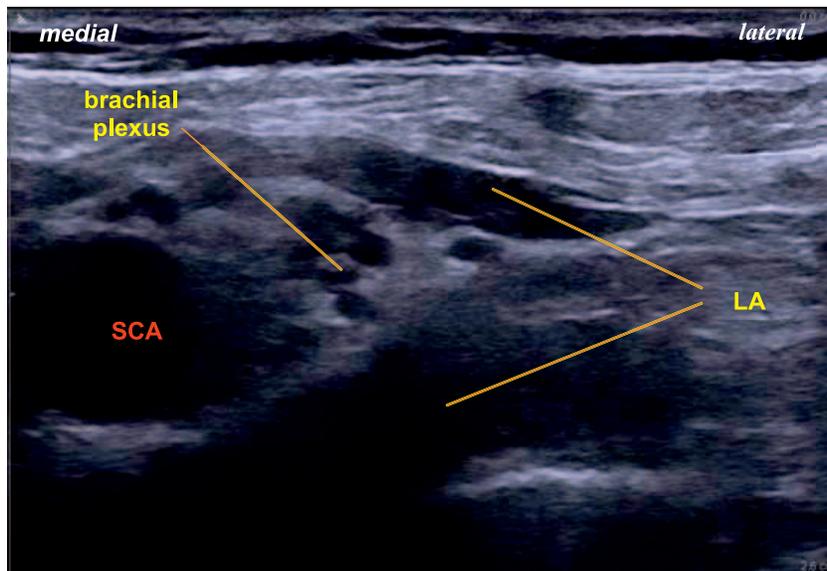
Ultrasound image demonstrating the brachial plexus surrounded by local anaesthetic.
